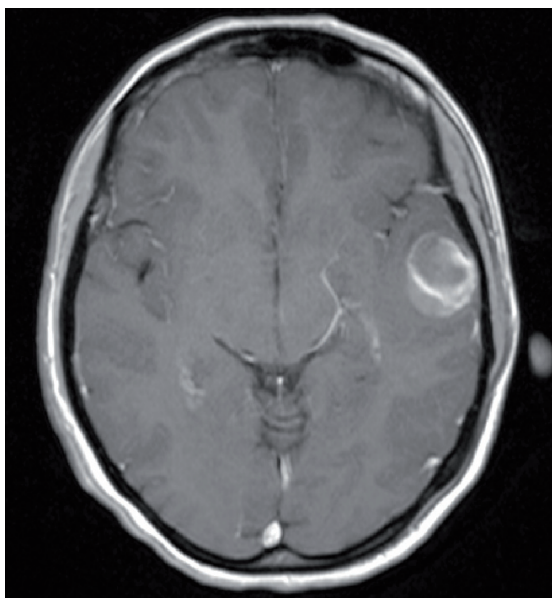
Type I cavernoma revealed in T1-weighted SE sequence.
